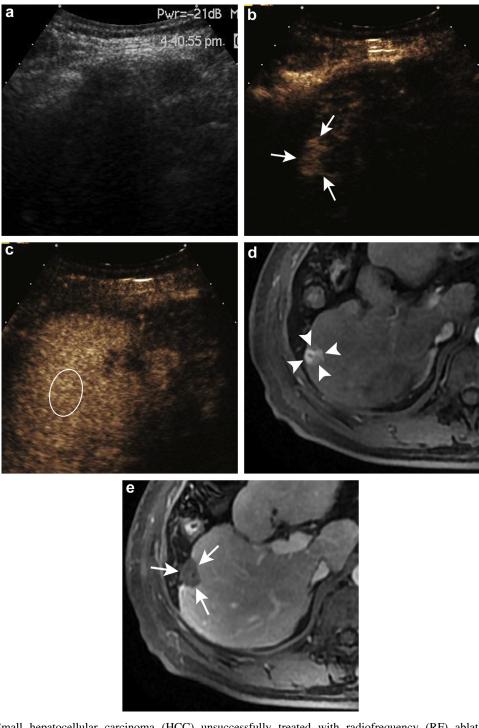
Small hepatocellular carcinoma (HCC) unsuccessfully treated with radiofrequency (RF) ablation under the contrast-enhanced ultrasound (CEUS) guidance in a 57-y-old man. (a) The HCC nodule could not be clearly visualized on conventional gray-scale ultrasound (US). (b, c) CEUS images in the hepatic arterial phase (26 s) and portal vein phase (48 s) after the injection of microbubbles show a 1.8-cm sized, only transiently hyper-enhanced nodule (arrows) without obvious washout of contrast agent (white ellipse). (d, e) Contrast-enhanced MRI performed 1 mo after CEUS-guided RF ablation shows a deviation of the ablation zone (arrows) close to the index tumor (arrowheads) in liver segment VII.
